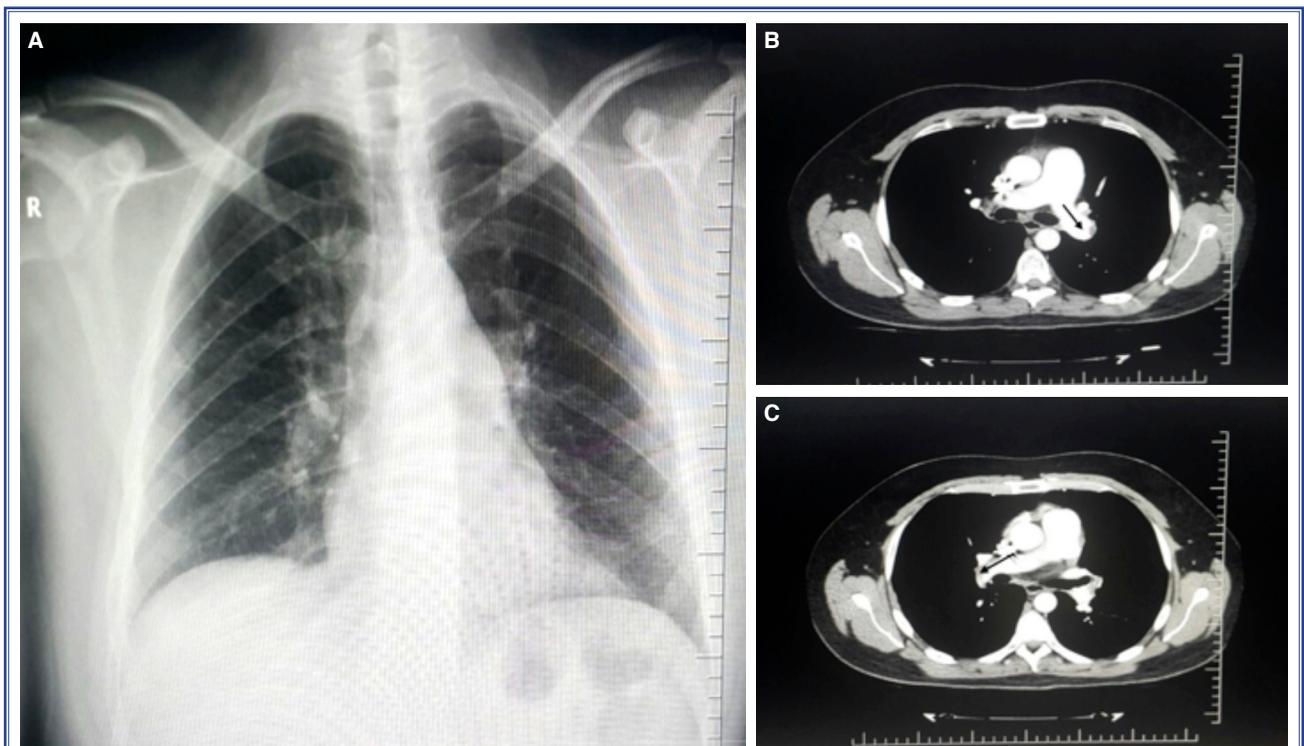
(A) A chest X-ray revealed no pathological findings. (B and C) Computed tomography thoracic angiography indicated defective filling of the bilateral pulmonary arteries consistent with a thrombus.
